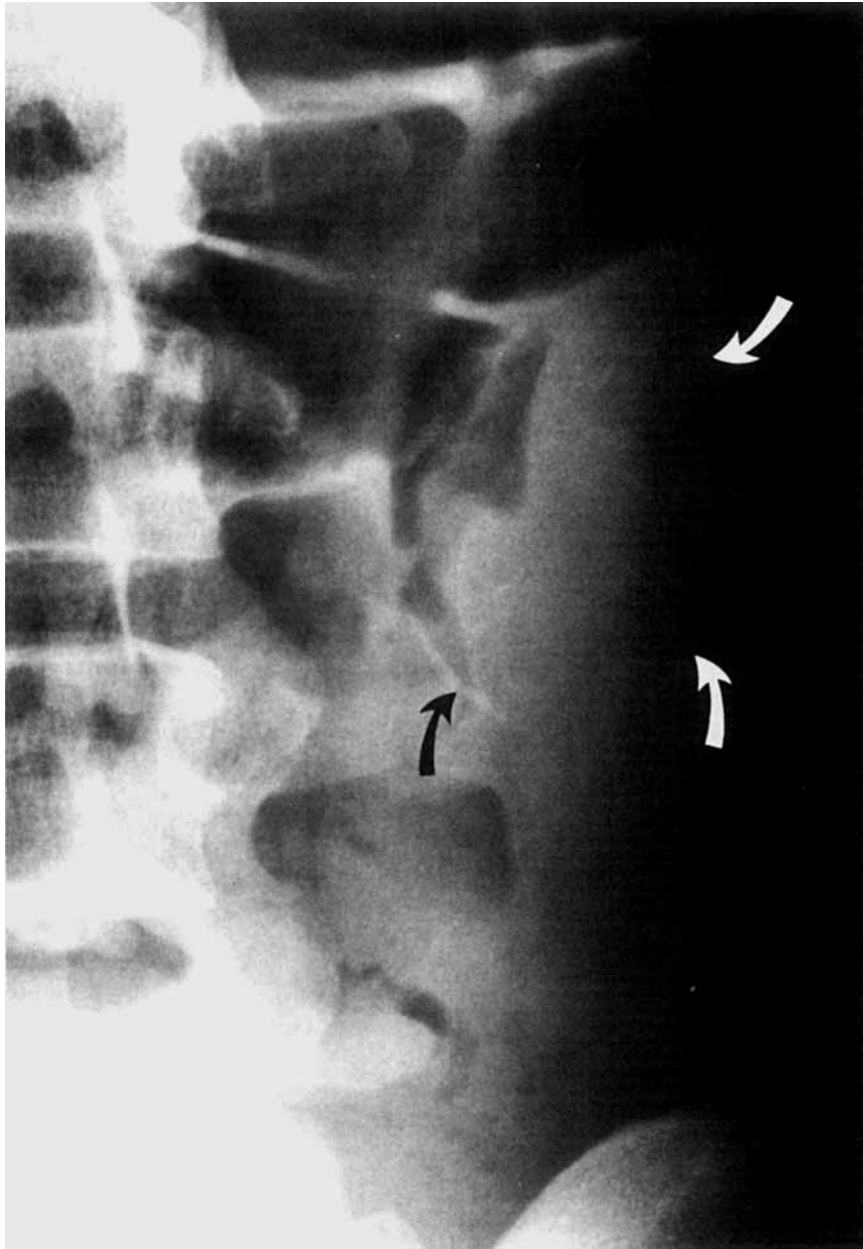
Coned-down radiograph of left upper quadrant. The faint calcified rim of the fetal calvarium is apparent (curved arrows).
